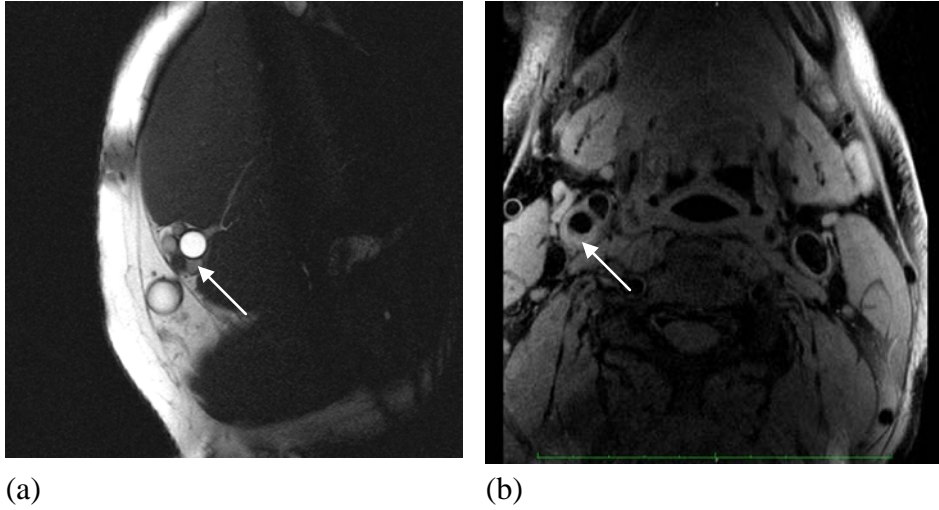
(a) MRI of brachial artery area- cardiac gated TrueFISP cine images, (b) Axial T1 weighted image of a carotid artery with atheroma in the internal carotid artery.
